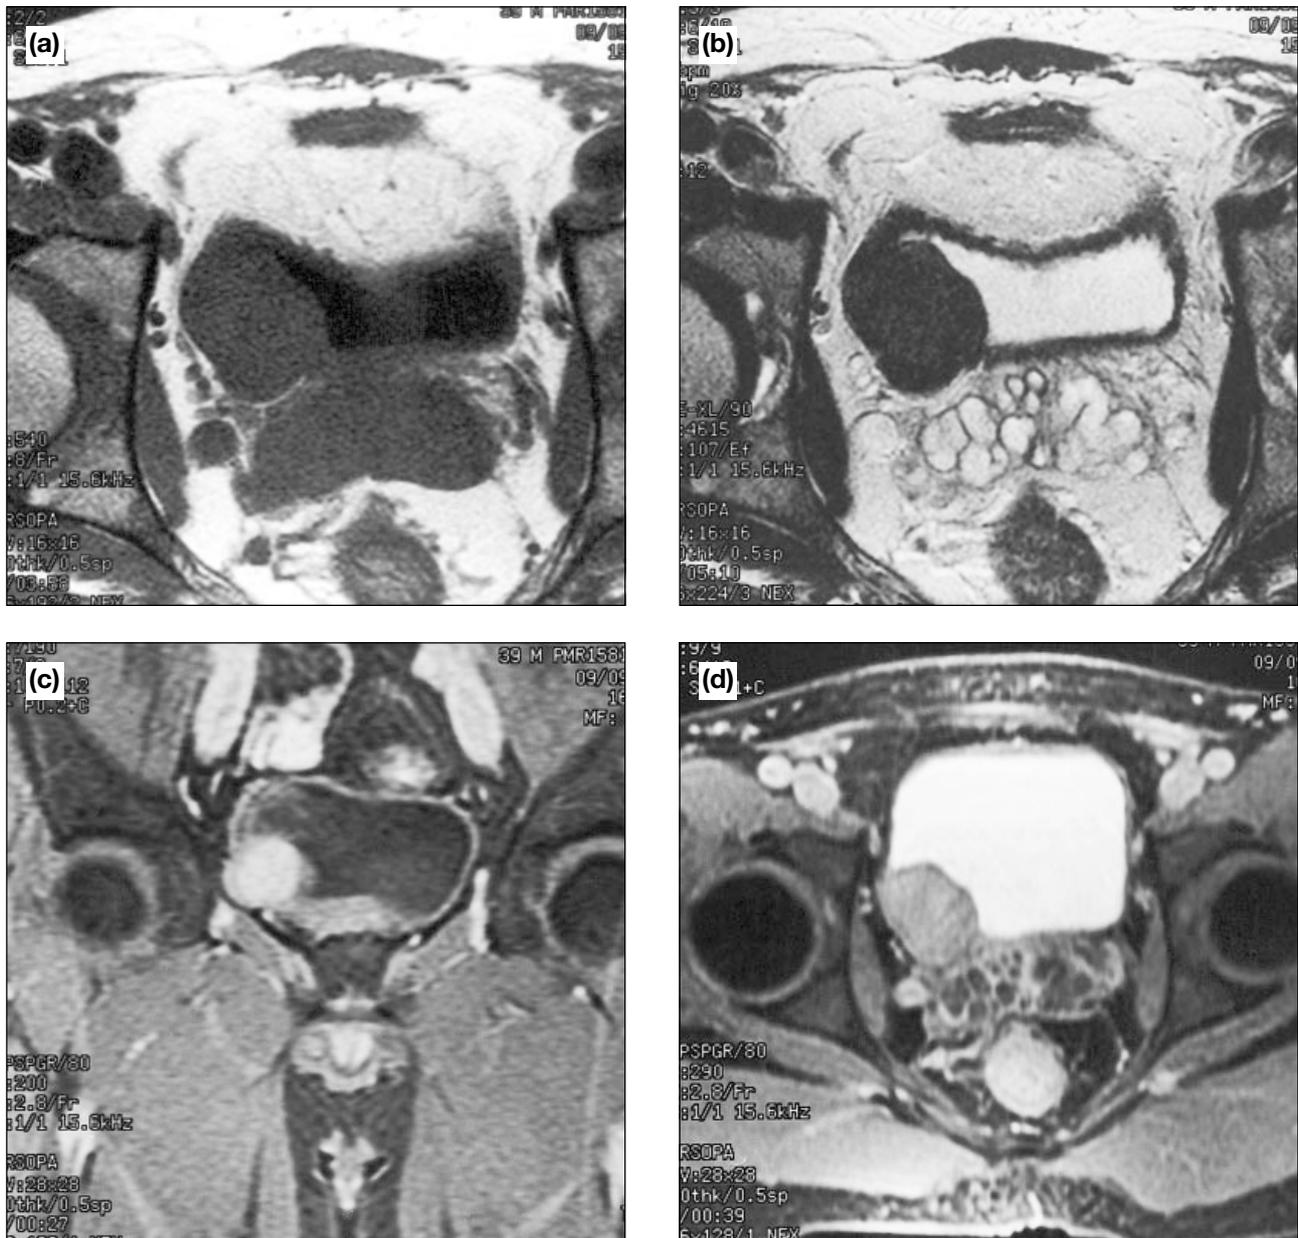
At magnetic resonance imaging, the lesion was homogeneously hypointense on both T1- and T2-weighted images (a and b, respectively). Mild uniform contrast enhancement (c) and a dark intact bladder mucosa (d) were seen post-gadolinium.
